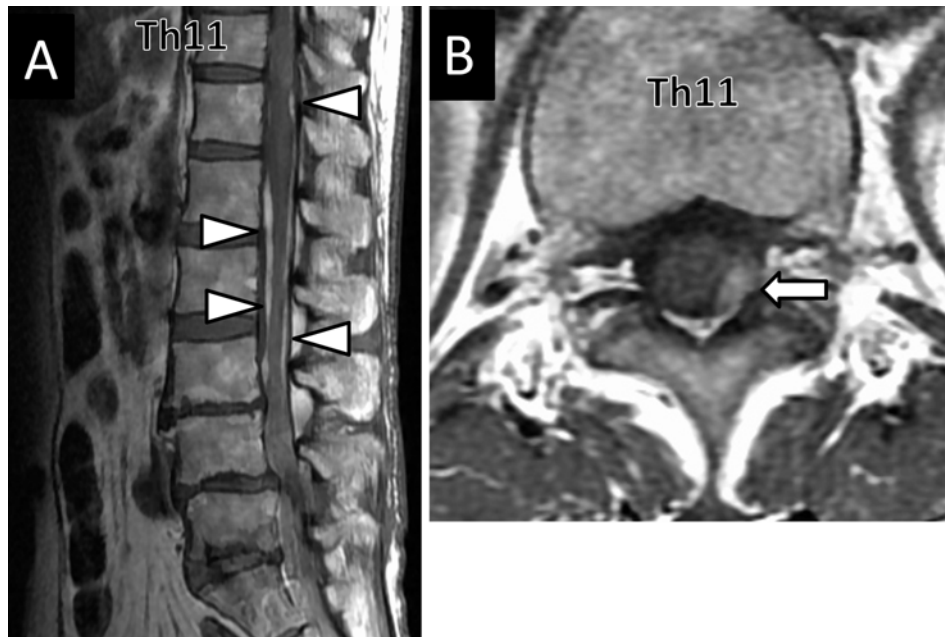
MRI performed 1 week after B-RTO. A: T1-weighted sagittal image shows subdural hematoma (arrowheads) as high-intensity area along inner edge of dural sac. B: T1-weighted axial image shows subdural hematoma as crescent high intensity (white arrow).
